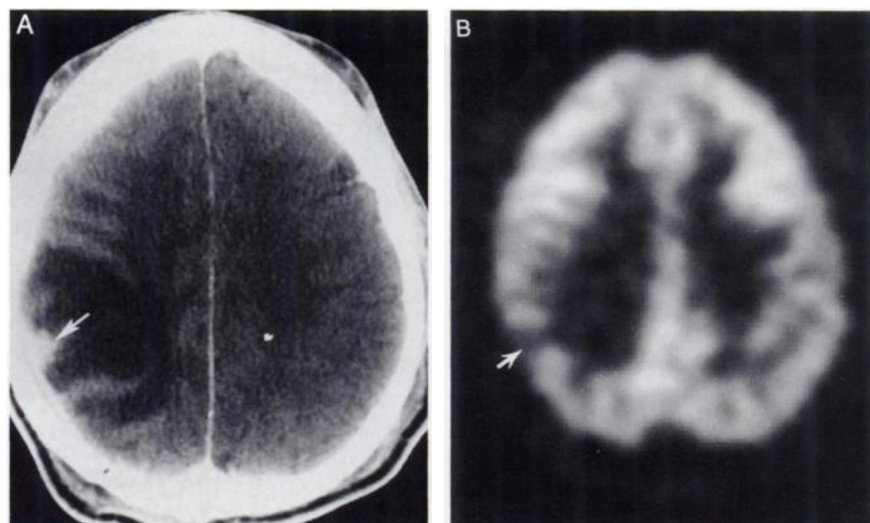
Patient 5 (Table 1). Enhanced CT scan (A) with cerebral edema around an enhancing mass lesion (arrow) in the right parietal region. FDG-PET study (B) shows a hypometabolic lesion with grade 2 FDG uptake (arrow) in the right parietal region. This lesion was a syphilitic gumma.
